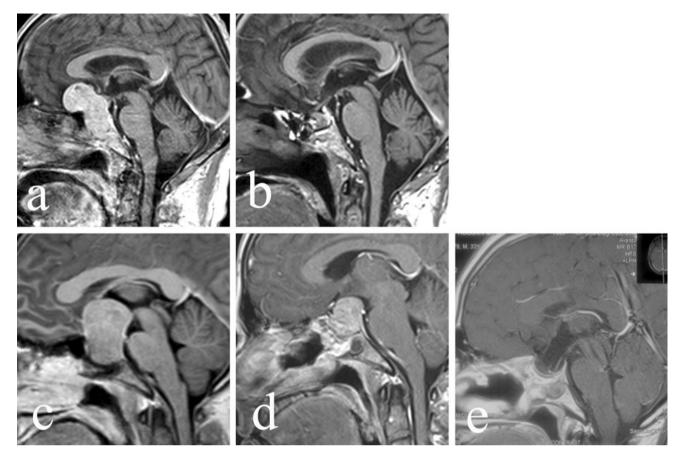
a Gadolinium enhanced T1w sagittal MRI showing a 4.5 cm Hardy's grade D pituitary macroadenoma with subfrontal extension. b Post-operative contrast T1w sagittal MRI following an extended endoscopic TS surgery showing no residual tumor. c Gadolinium enhanced T1 w sagittal MR image showing a 4 cm Hardy's grade C
